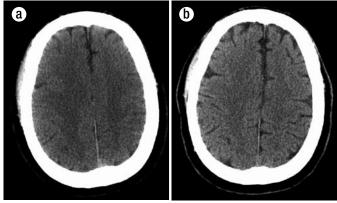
Initial head CT and short-term follow-up head CT. (a) CT from admission reveals diffuse edema with effacement of sulci near the vertex. (b) Follow-up CT 2 days after admission shows interval resolution of edema.
